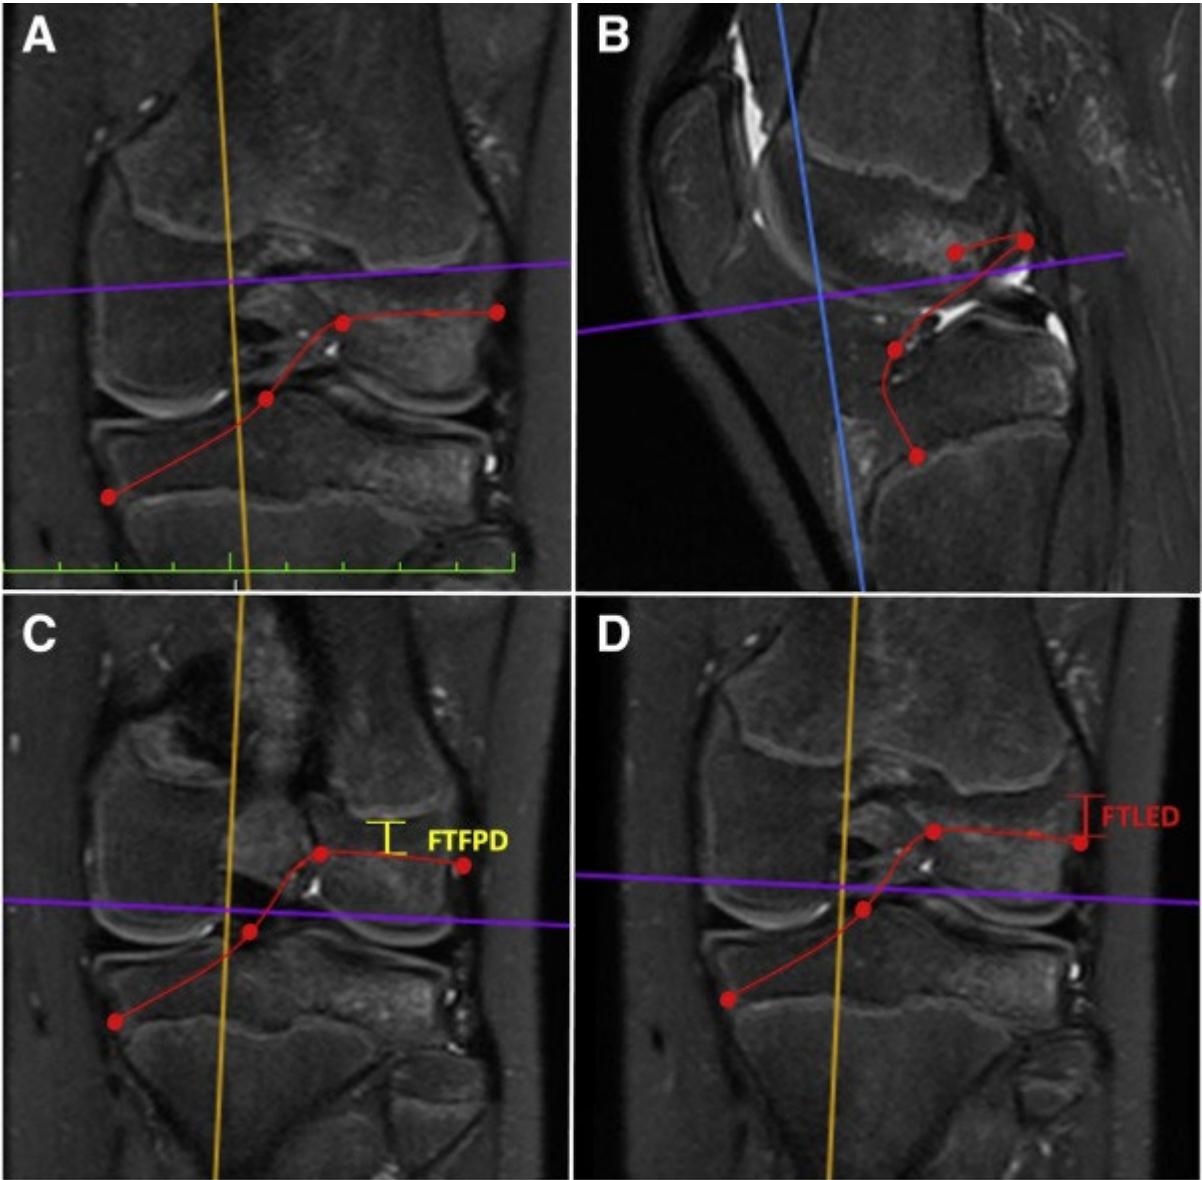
Three-dimensional (3D) measurements performed on the 3D magnetic resonance imaging of a left knee. All-inside all-epiphyseal pediatric anterior cruciate ligament reconstruction on (A) coronal and (B) sagittal cuts. In addition, on the coronal cuts, the (C) femoral tunnel – femoral physis distance (FTFPD, yellow line) and the (D) femoral tunnel – lateral femoral epicondyle distance (FTLED, red line) were measured.
